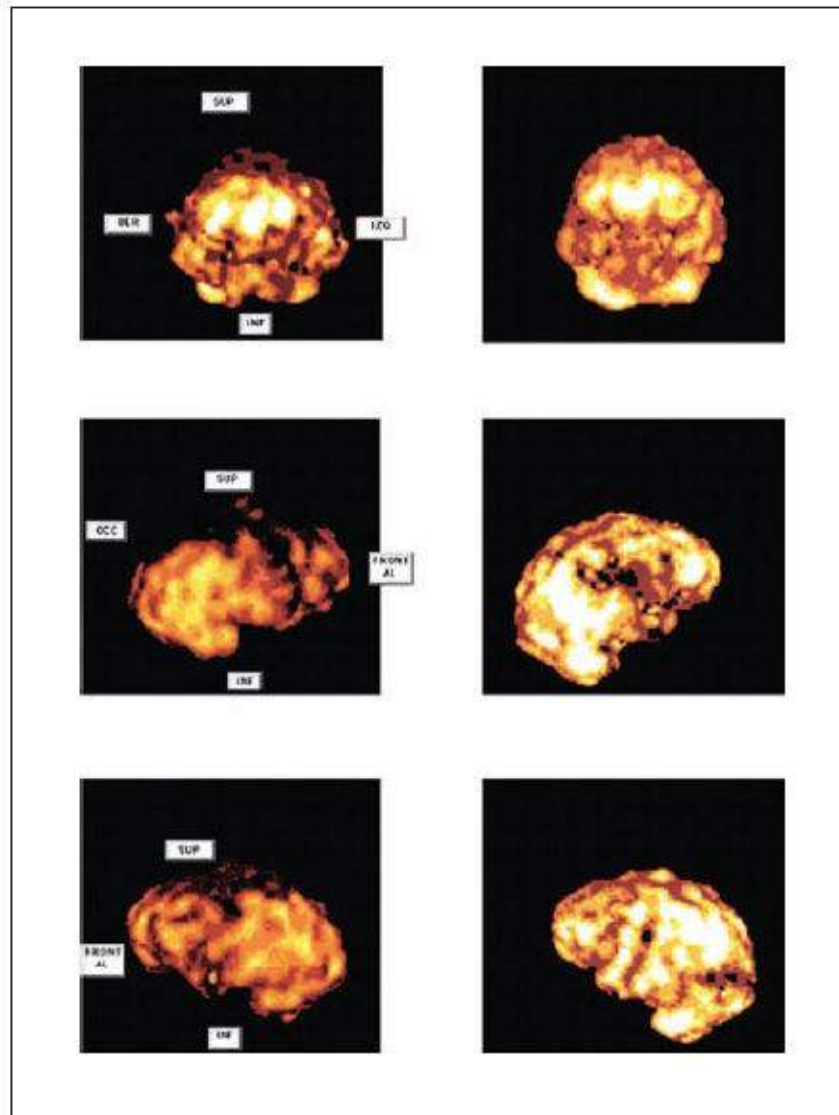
SPECT scan of the brain of a student with ADHD before and after supplementing with NADH.
